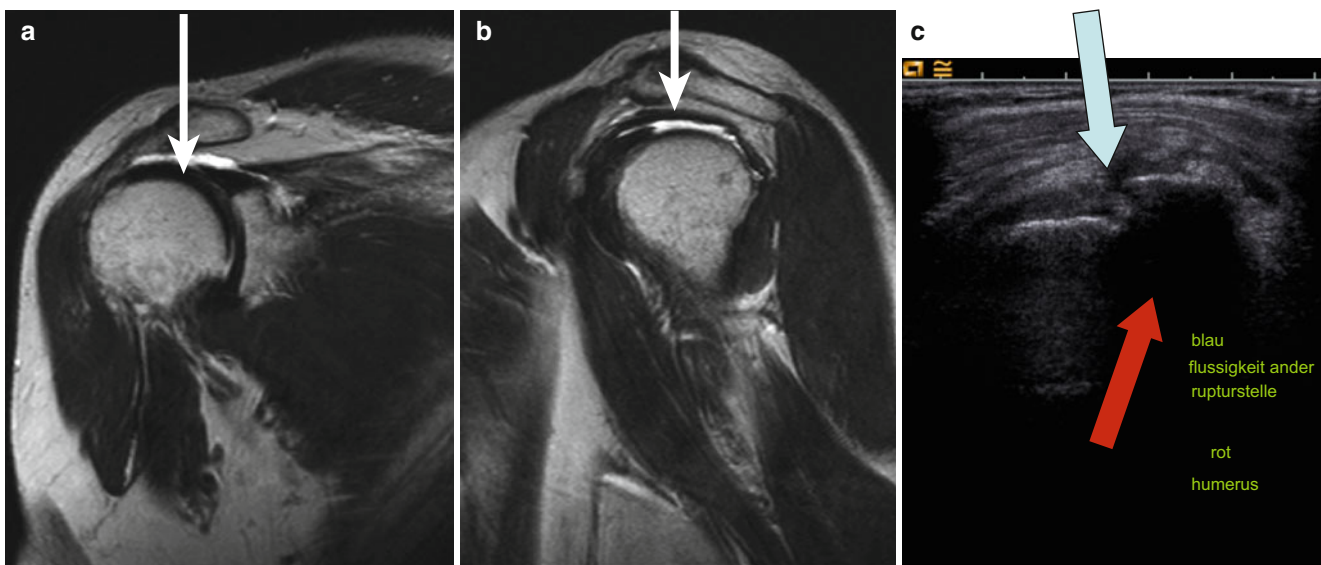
Rotator cuff rupture: (a, b) MR of shoulder showing the site of tendon rupture (*white arrow*). (c) Ultrasound of the shoulder: *red arrow* humerus, *blue arrow* fluid extravasate at the site of the lesion
